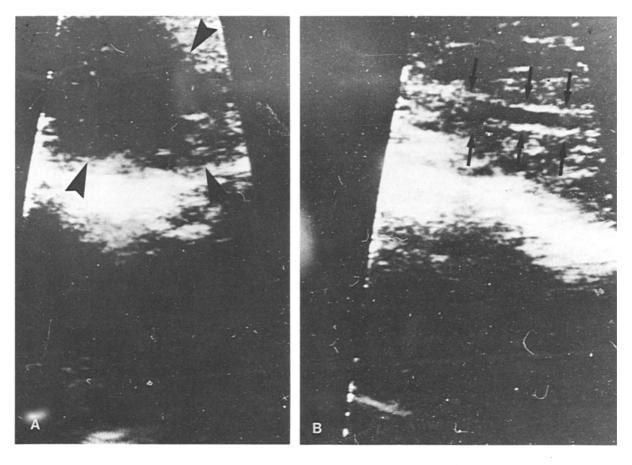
Ultrasonographic visualization of A. cephalic insulinoma (arrowheads) and B. normal Wirsung duct (arrows).
